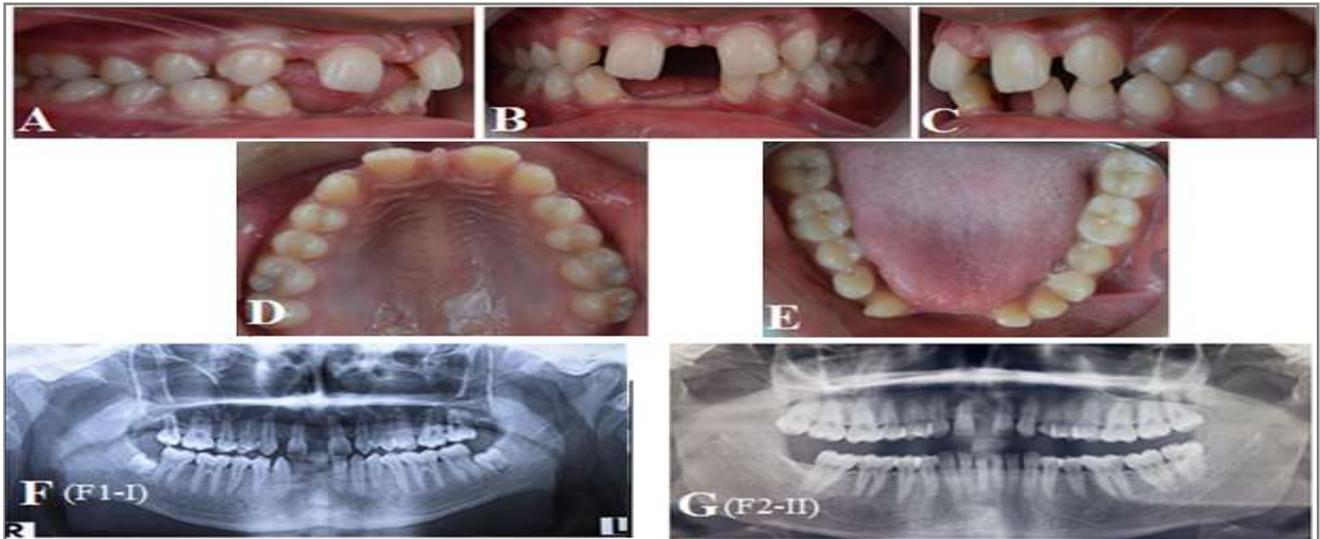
Phenotype of family 1 (F1) and family 2 (F2), Intra oral photograph (A) Right occlusal view, (B) Front occlusal view, (C) Left occlusal view, (D) Upper occlusal view, (E) lower occlusal view, (F) Panoramic radiograph of proband (F1-I) show missing teeth 12, 18, 22, 28, 31, 41, 42 (FDI number system) (G) Panoramic radiograph of proband (F2-II) show missing teeth 12, 22, 48.
